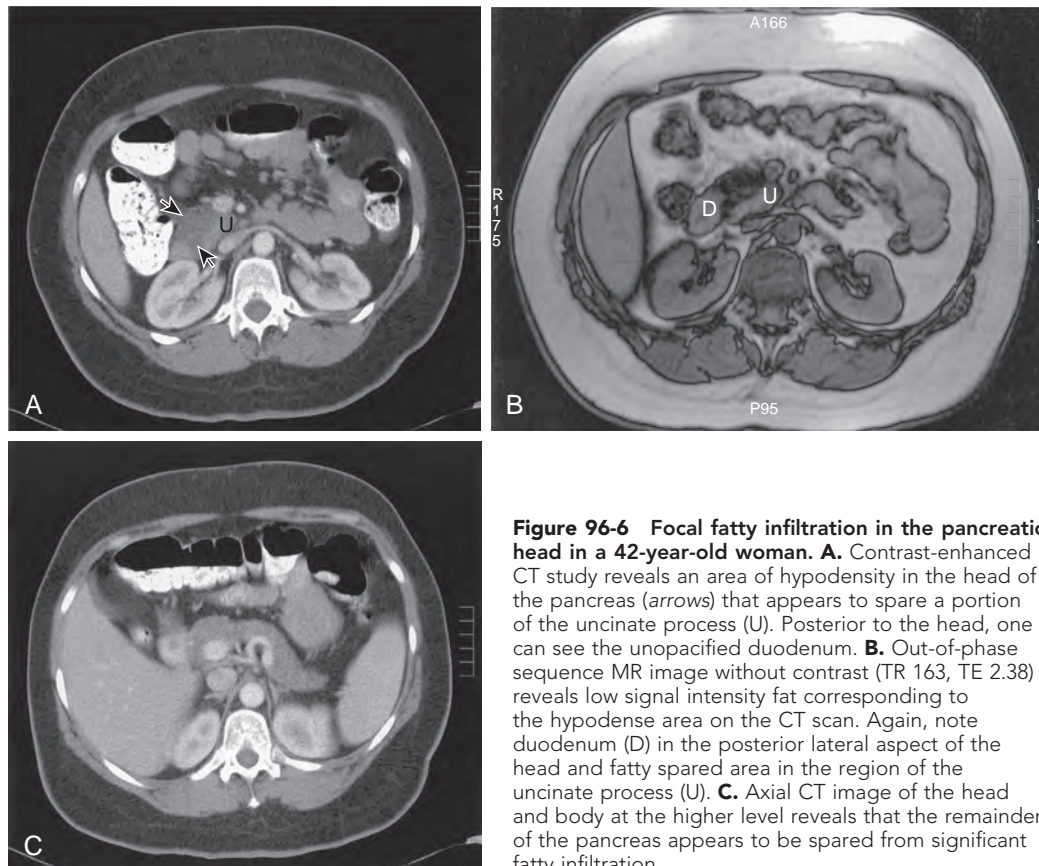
Focal fatty infiltration in the pancreatic head in a 42-year-old woman. A. Contrast-enhanced CT study reveals an area of hypodensity in the head of the pancreas (arrows) that appears to spare a portion of the uncinate process (U). Posterior to the head, one can see the unopacified duodenum. B. Out-of-phase sequence MR image without contrast (TR 163, TE 2.38) reveals low signal intensity fat corresponding to the hypodense area on the CT scan. Again, note duodenum (D) in the posterior lateral aspect of the head and fatty spared area in the region of the uncinate process (U). C. Axial CT image of the head and body at the higher level reveals that the remainder of the pancreas appears to be spared from significant fatty infiltration.
